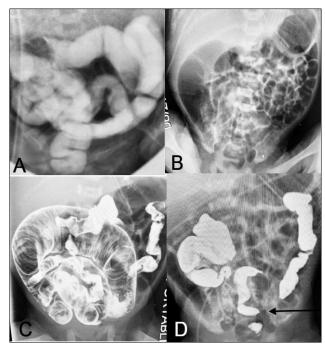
A) Contrast outlines the colon. B) X-ray abdomen showing dilated small bowel loops. C) Contrast outlines the dilated small bowel loops. D) Ultimately the contrast evacuates to the rectum (Arrow)
